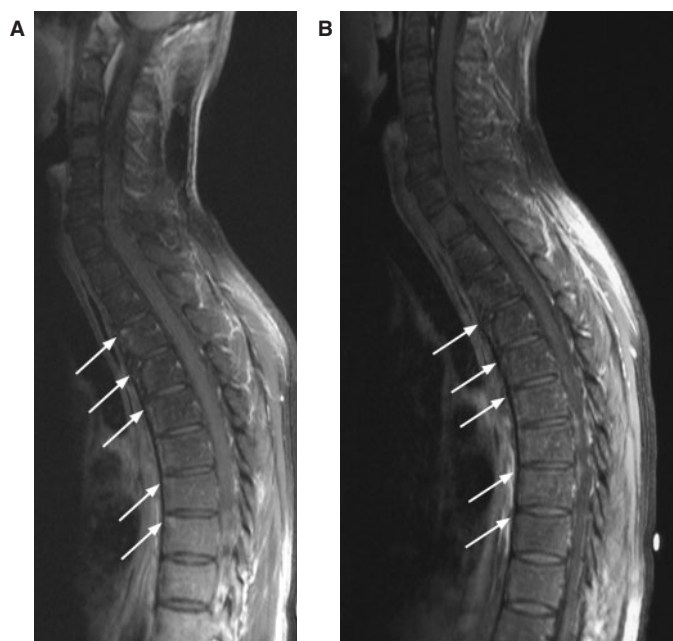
Sagittal T1-weighted fat-suppressed post-contrast MR images of cervicothoracic spine.
